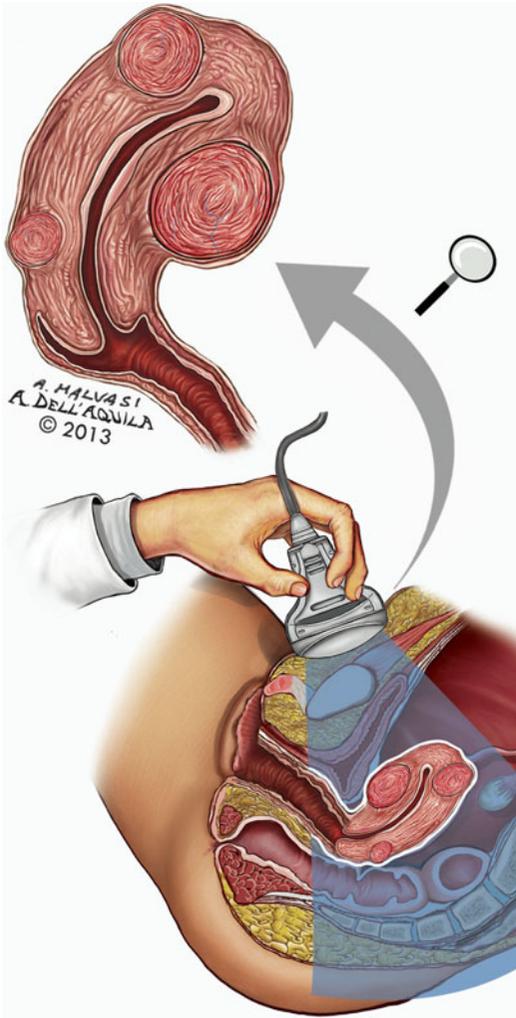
Ultrasound examination is a sensitive instrumental method of fibroids' diagnosis, but often occasionally detects clinically insignificant fibroids
